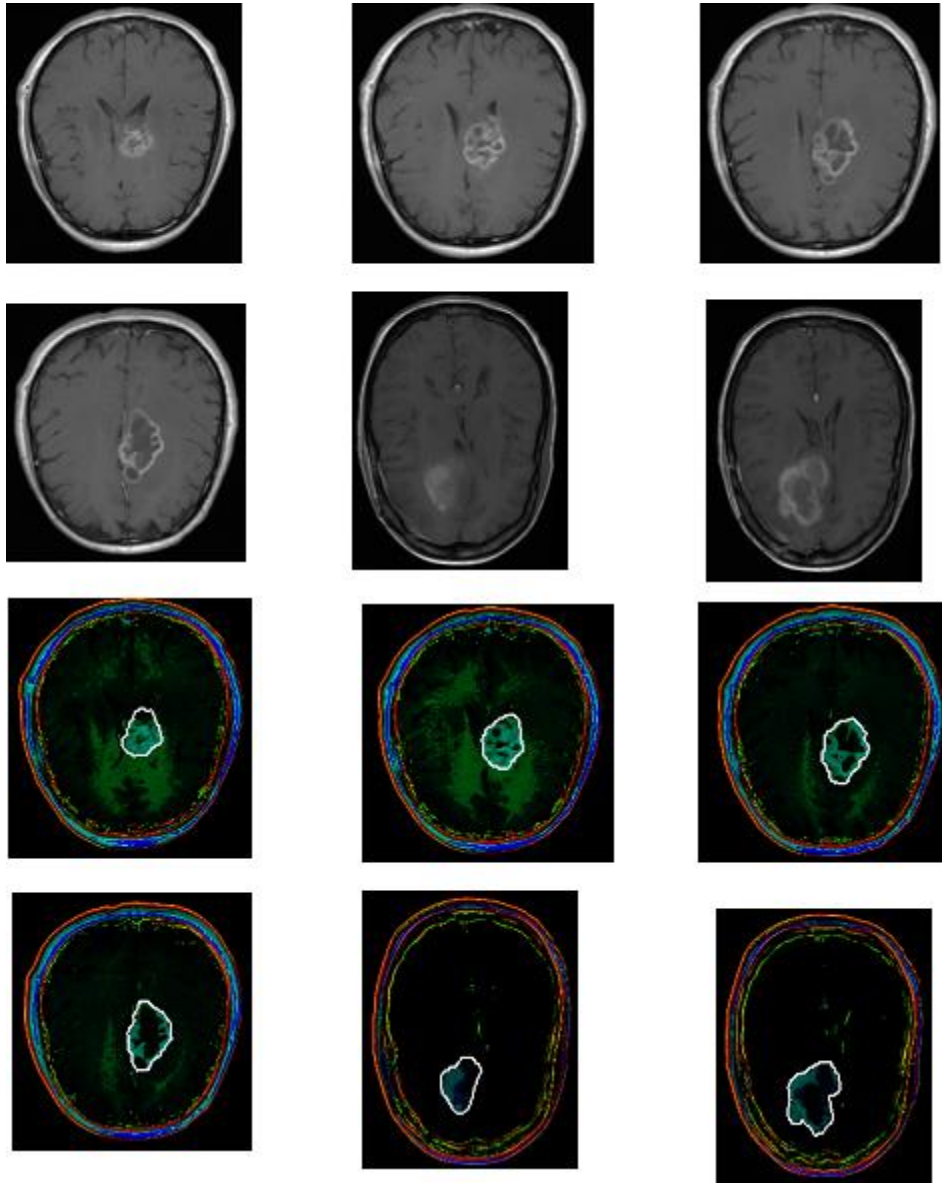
Signature map results for patients with cancerous tissues composed of dark objects (eg. cyst, necrotic structures etc). White lines are delineations from the radiologist used as the gold standard: Original T1-W MR images (1st and 2nd row) and the respective signature maps generated using the proposed scheme (3rd and 4th row).
